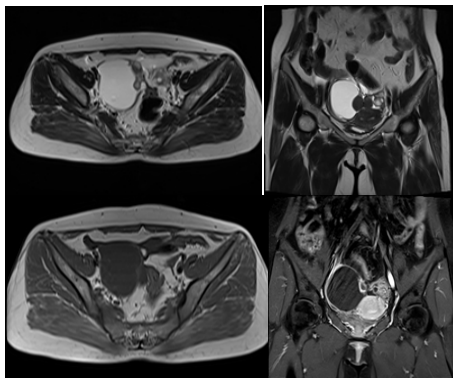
MRI pelvis showing multiloculated right tuboovarian abscess.
